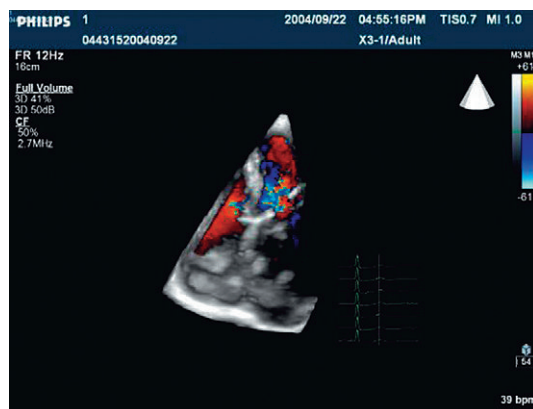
A 2D projection of a 3D colour Doppler image onto a display screen. The image can be rotated to provide a 3D impression of the flow in the 3D volume scanned. Courtesy of Philips Medical.
